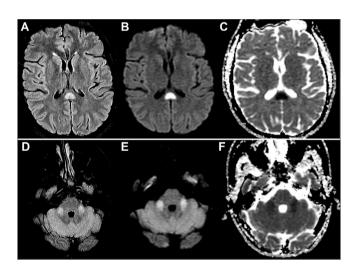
Noncontrast MRI brain, demonstrating T2/FLAIR hyperintensity (A) and increased diffusion restriction on DWI (B) and ADC-map (C) in the splenium of the corpus callosum, with similar findings in both middle cerebellar peduncles (D–F).
